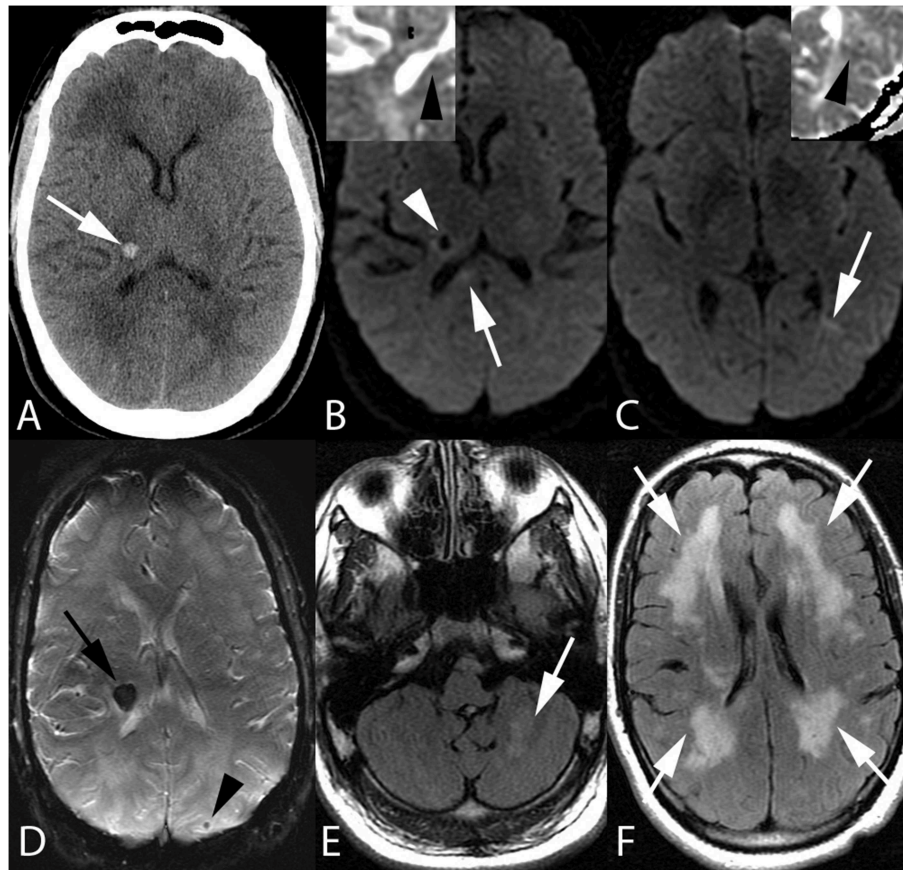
Fifty-five-year-old man with end stage renal disease and severe hypertension. Axial CT image (A) reveals a focal parenchymal hemorrhage at the junction of the right thalamus and posterior limb of the right internal capsule (arrow). Axial DWI images with ADC inserts (B,C) show foci of diffusion restriction within the right corpus callosum splenium (arrow, B) and left temporo-occipital periventricular white matter (arrow, C). ADC maps confirm diffusion restriction (insert B,C, arrowheads). Again seen is right thalamocapsular hematoma (arrowhead, B). Axial SWI image (D) demonstrates blooming of right thalamocapsular hematoma (arrow) in addition to a punctate hemorrhage within left parietal subcortical white matter (arrowhead). Axial FLAIR images (E,F) show left cerebellar (arrow, E) and confluent bilateral frontoparietal (arrows, F) edema.
